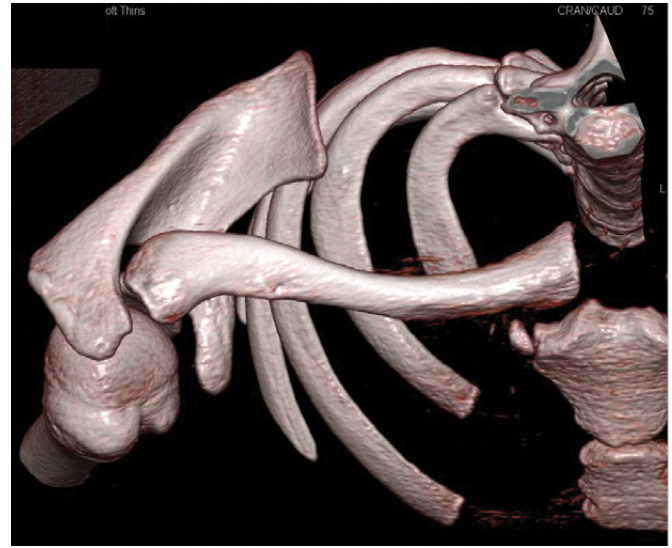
3D CT, Posterior Dislocation/Right SC Joint
